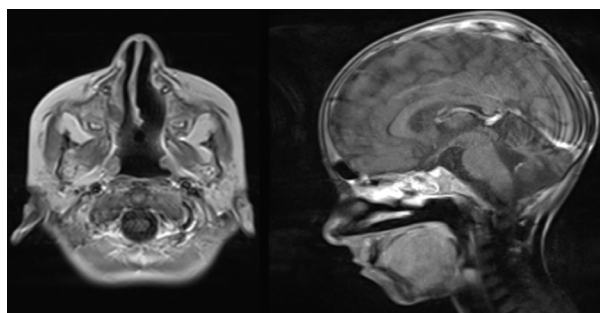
Post-treatment magnetic resonance imaging image.
